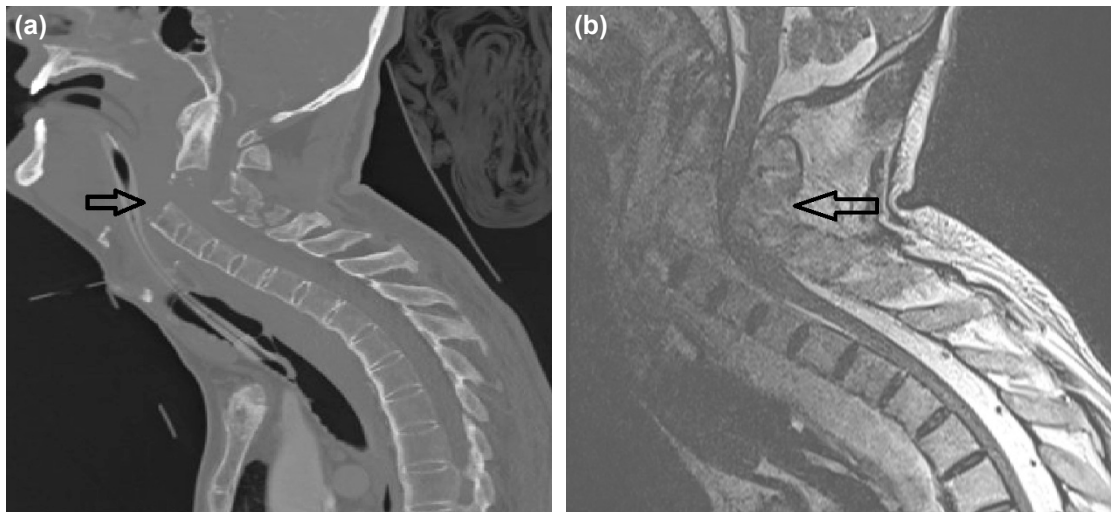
(a) Sagittal computed tomography scan showing complete diastasis between the vertebral bodies of C2 and C3 (black arrow). (b) T2 weighted sagittal magnetic resonance imaging displaying anterior cervical dislocation fracture at C2-3, apparent compression, and narrow calibration of the spinal cord (black arrow).
